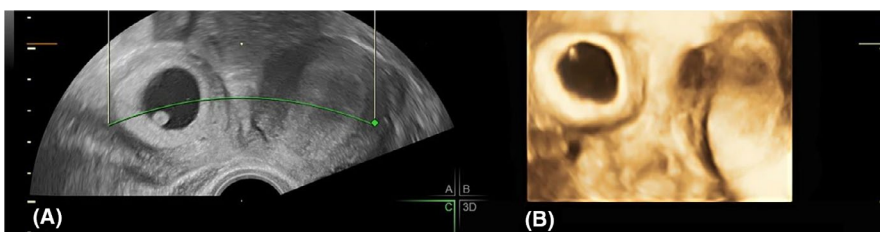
A, 2D ultrasound showing transverse view of unicornuate uterus on left side, pregnant rudimentary horn on right side. B, 3D configuration of the unicornuate uterus and pregnant rudimentary horn
